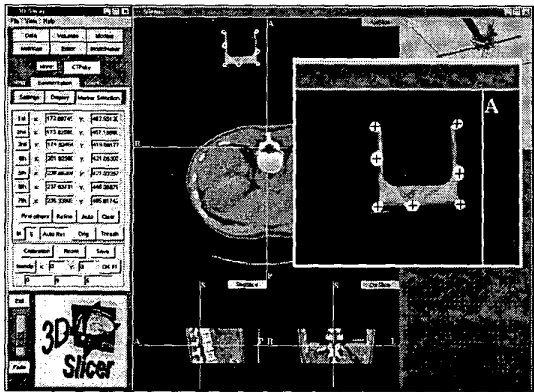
Treatment planning display and CT image of the end-effector shown in Figure 4D. (Tanacs et al., 2001)
